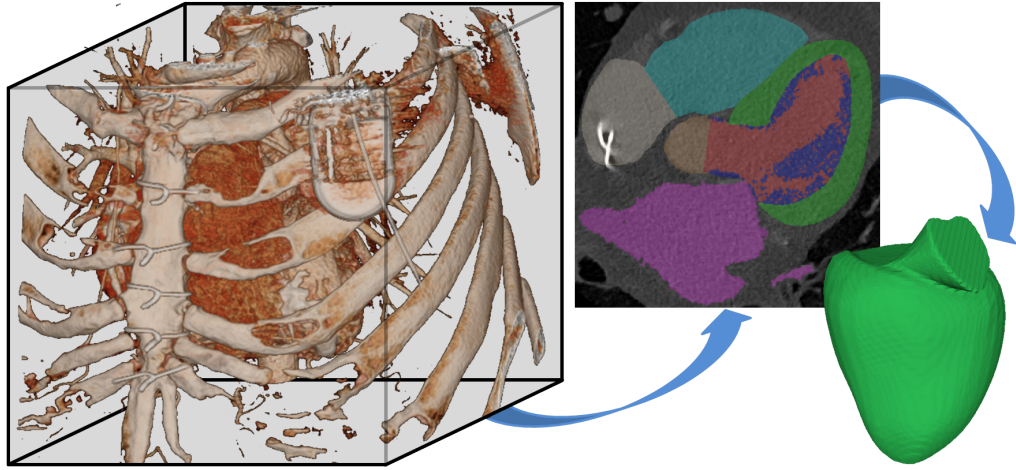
Model extraction from CT data. The CT volume (left) is automatically segmented. The 2D image slice (middle) shows the structures being segmented with colored labels. The 3D LV mesh model (right, green) is generated from the LV myocardium (green), the blood pool (red), and the trabeculations (dark blue).
